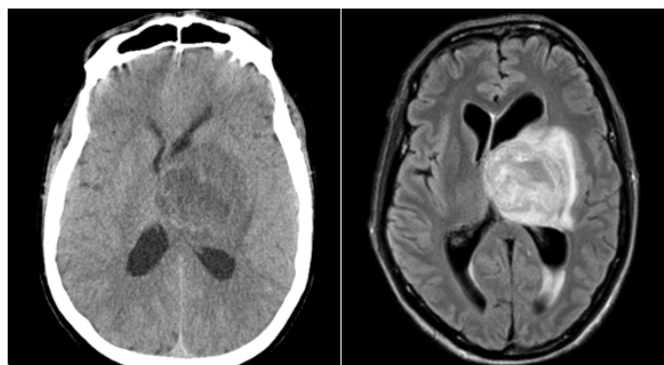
Initial CT scan and MRI pictures of the left side thalamic abscess.
